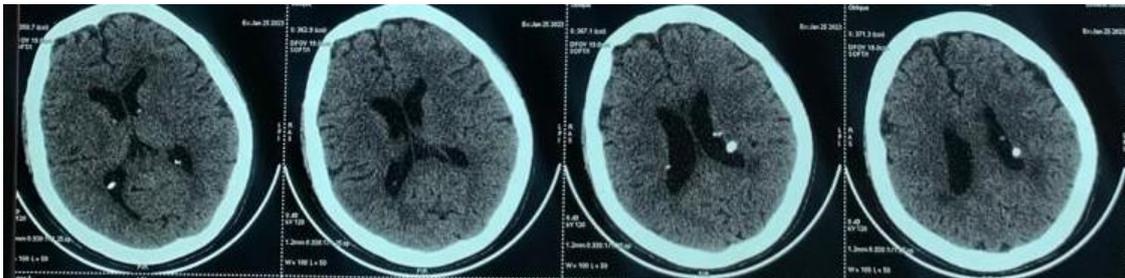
Brain CT scans: showing calcified nodules in the subependymal area
